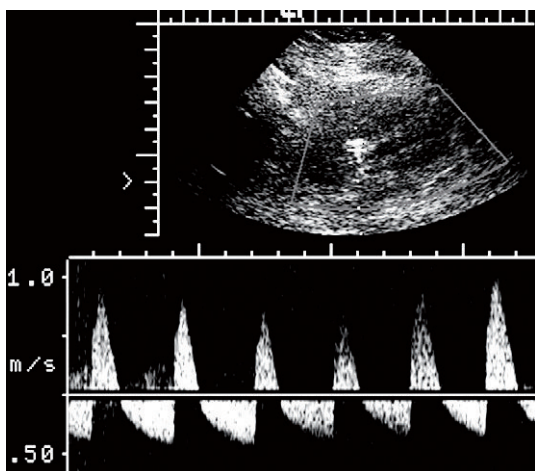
Spectral Doppler tracing of the main renal transplant artery in a recent recipient with a rapidly rising creatinine. The arterial waveform reveals to-and-fro flow with the retrograde component being essentially equal to antegrade flow. The resistive index measures approximately 140%. No flow could be identified by spectral or colour Doppler in the renal veins. Complete venous thrombosis was confirmed at angiography.
